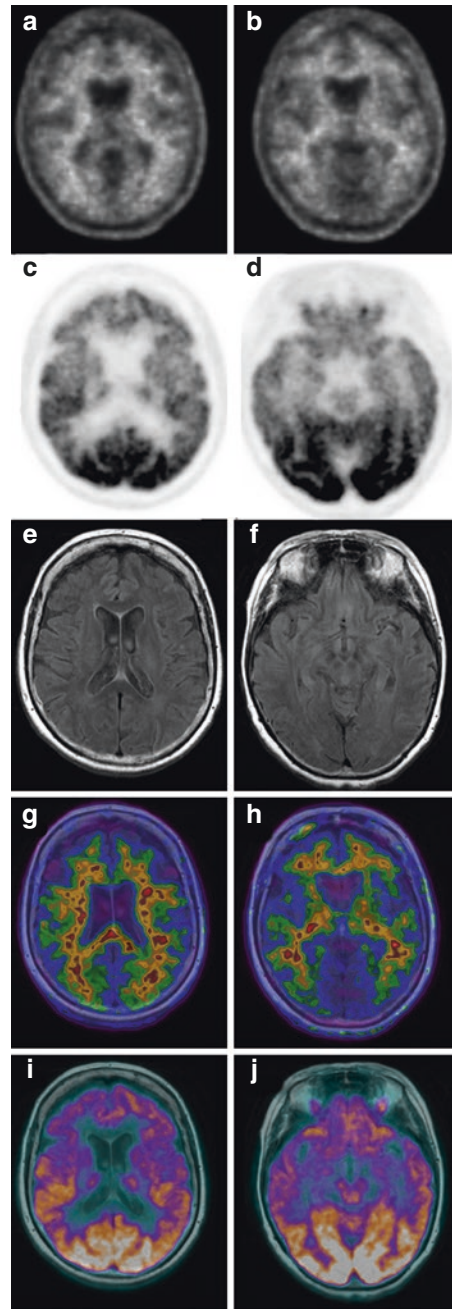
In (a) and (b) we report the axial views of a ^{18}F -florbetapir PET showing no significant amyloid burden in brain in a 66-year-old female subject with clinical suspect of frontotemporal dementia. In (c) and (d) we report the axial views of ^{18}F -FDG PET in the same subject, showing a decrease of brain glucose consumption in the frontal and temporal lobes bilaterally. MRI scans are showed in (e) and (f) and PET/MR fusion imaging of ^{18}F -florbetapir and ^{18}F -FDG are showed in (g, h) and (i, j) respectively
